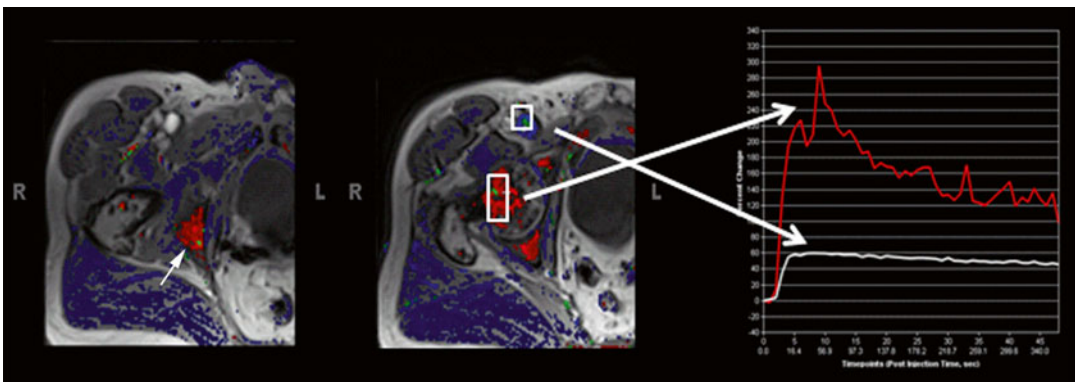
Axial DCE-MRI of the right femur lesion shows abnormal perfusion (red) in the bone marrow (arrow) with washout kinetics characteristic for metastasis. Courtesy of Michael A. Jacobs, Ph.D. (JHU)
